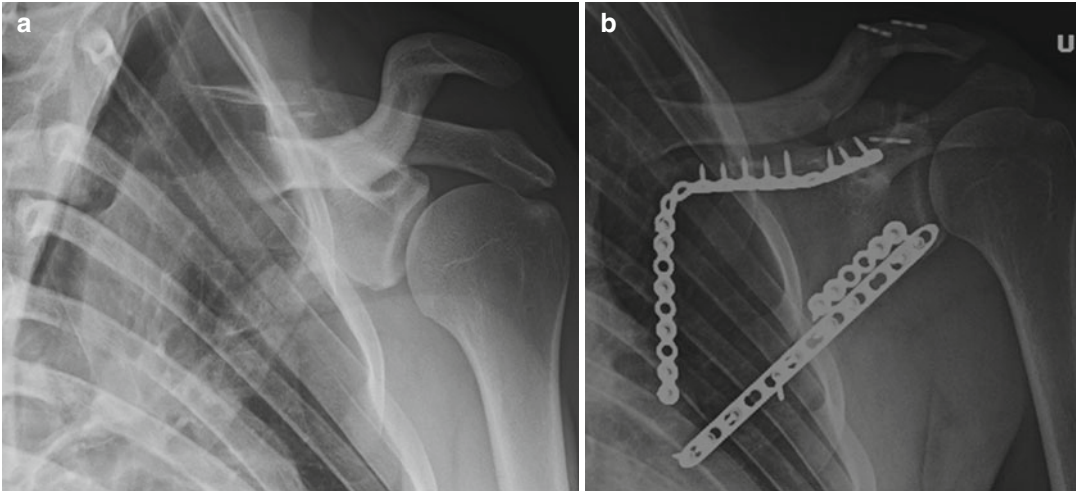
(a) Grashey radiograph demonstrating an acromioclavicular dislocation as well as a comminuted extraarticular scapula fracture. (b) Postoperative image showing the reduced acromioclavicular joint with a
